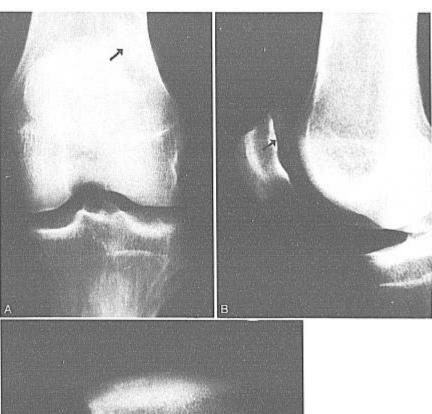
Radiographs of AP (A), lateral (B), and patellar (C) views show a displaced fracture superolateral patella. *Solid arrow* points to the unstable painful fragment. This is consistent with an underlying asymptomatic bipartite patella, Saupe Type III.
